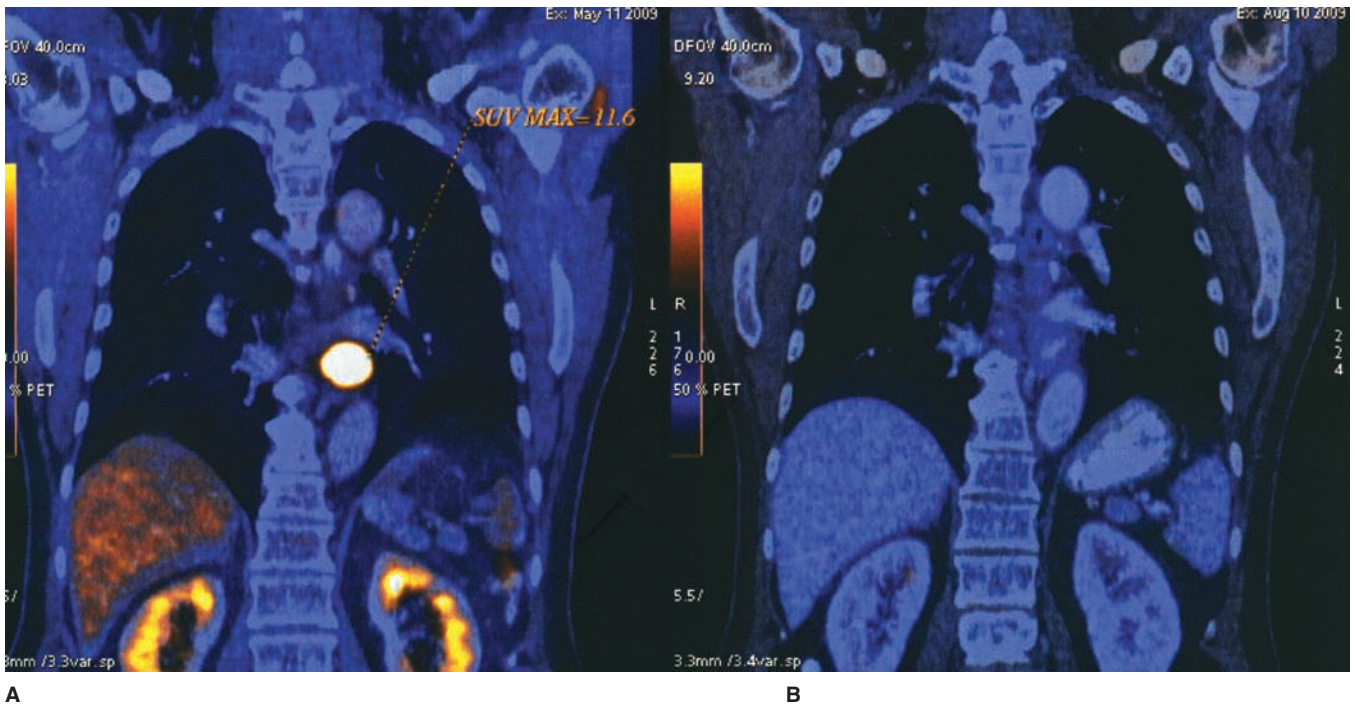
PET/CT before (A) and after (B) chemoradiation therapy; the tumor has become completely eumetabolic.
